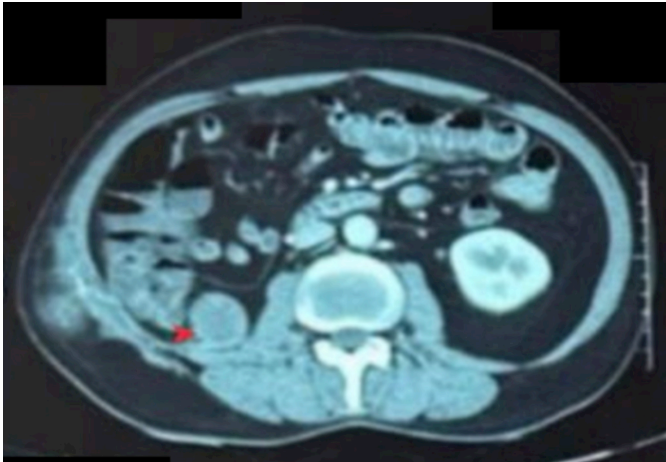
Post-metastasectomy Contrast-enhanced computed tomography axial view showing a residual tumor in the renal bed (red arrowhead).
